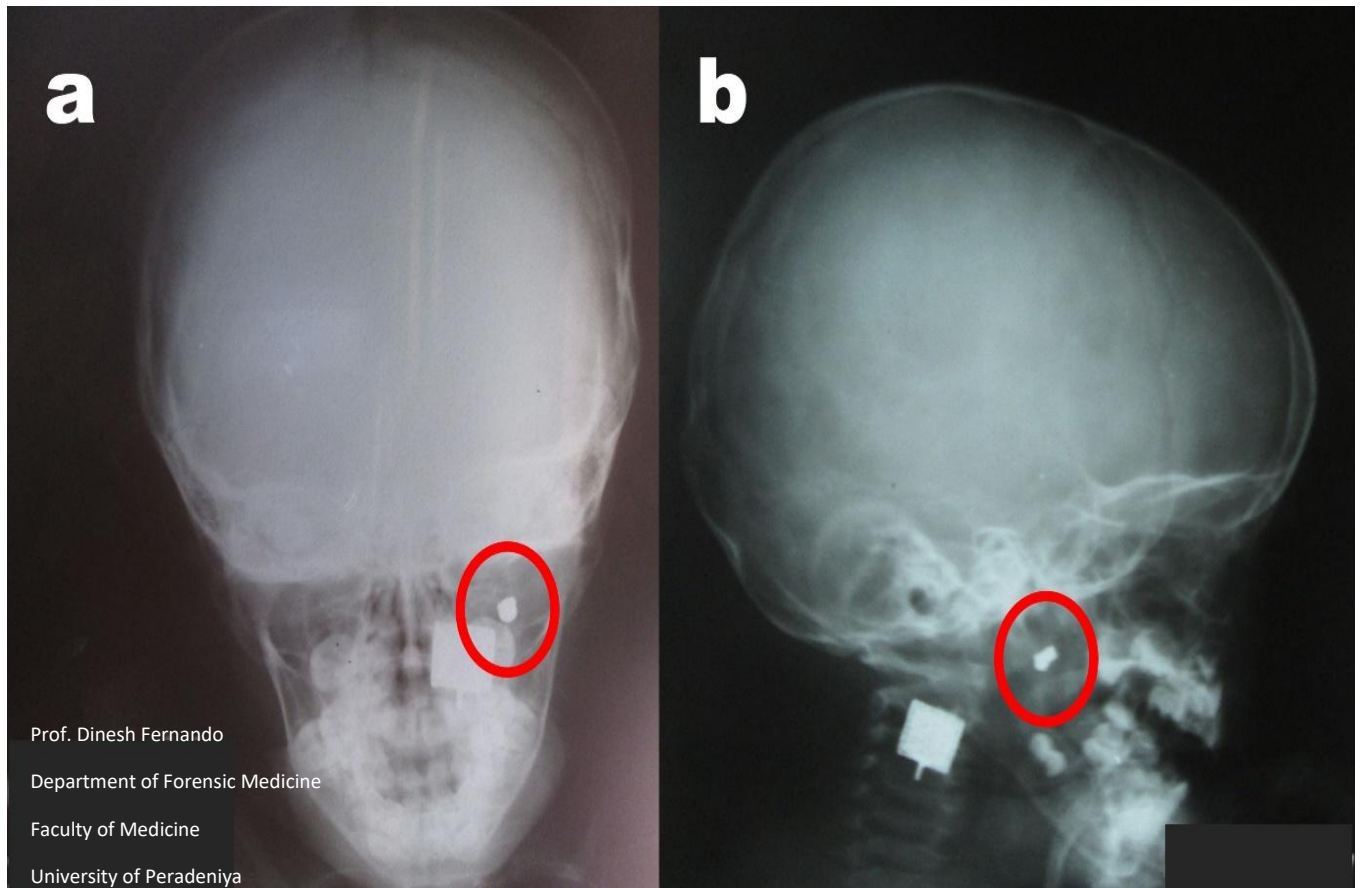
X-ray skull showing a diablo shaped radio-opaque object in the left side of the face (circle); (a) PA view, (b) lateral view
